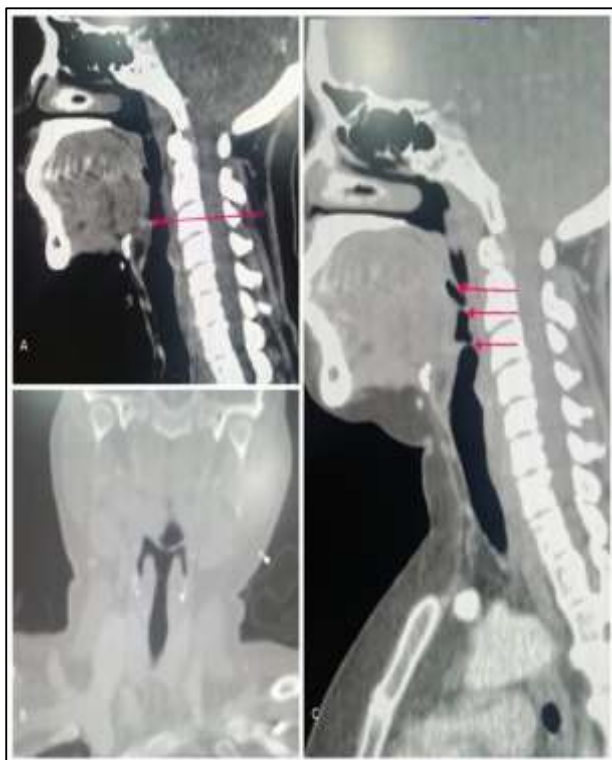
(A-C): Contrast enhanced CT neck findings. Rudimentary epiglottis on sagittal section, a pharyngeal web seen on coronal section, three pharyngeal bands in oropharynx on sagittal section.
